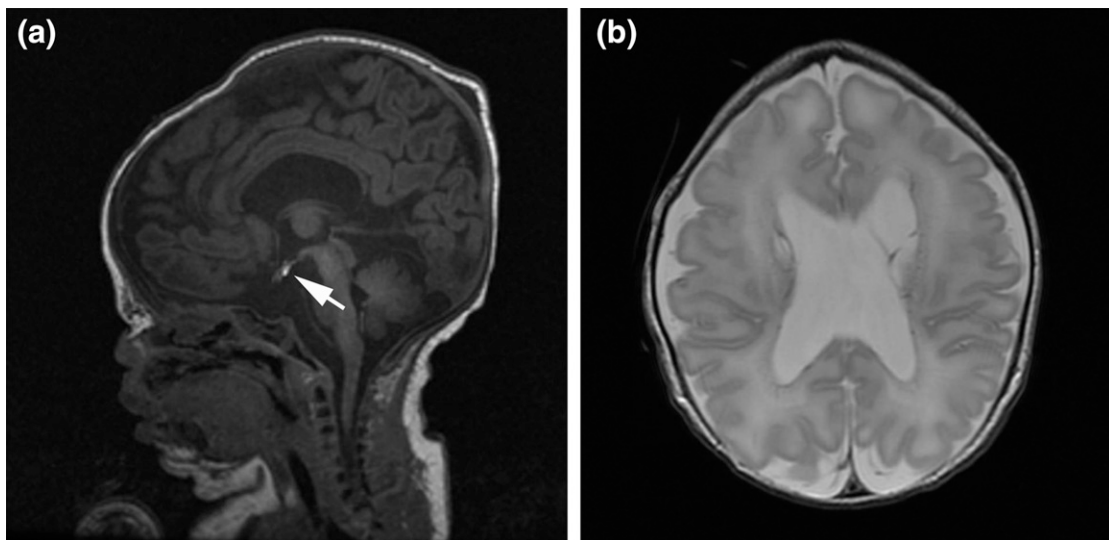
Brain magnetic resonance images showing brain and craniofacial anomalies. (a) Sagittal T₁-weighted image showing ectopic location of the posterior pituitary bright spot (arrow), consistent with an ectopic posterior pituitary with a flattened and empty sella turcica. Micrognathia is also apparent. (b) Axial T₂-weighted image showing absent septum pellucidum with mildly enlarged lateral ventricles.
